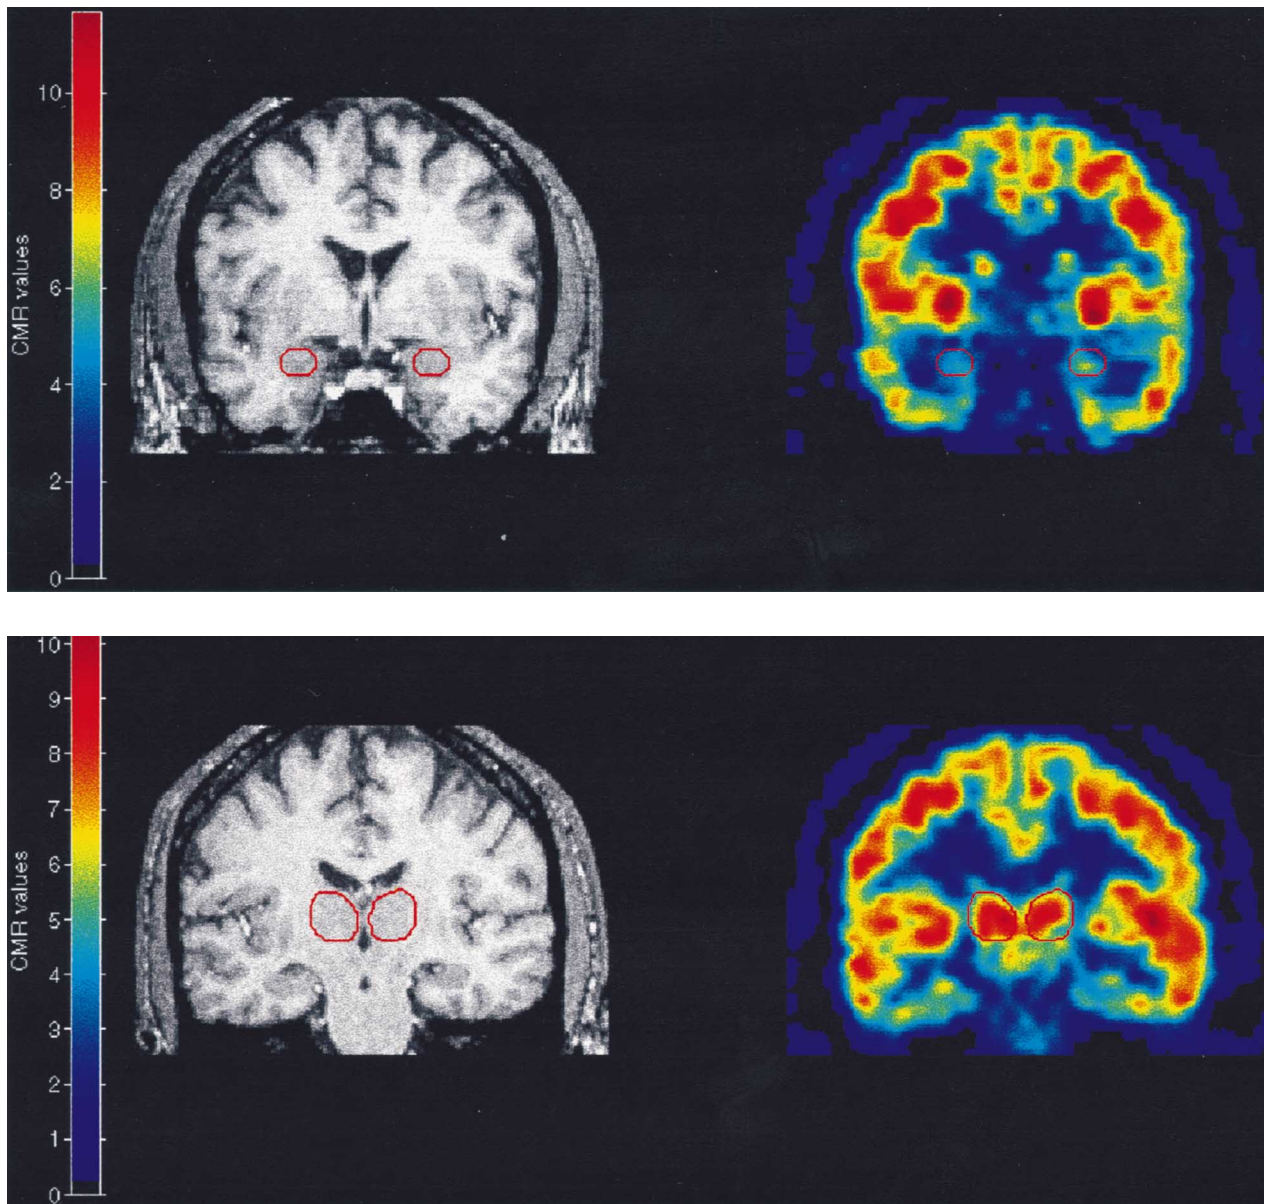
PET-MRI co-registration and amygdalar (a) or thalamic (b) ROI delineation. This figure presents representative image planes in the coronal orientation for one participant. The PET image planes are presented beside their corresponding co-registered MRI planes.²¹ Each actual amygdalar ROI included data from 5–8 planes and thalamic ROIs contained data from 25–41 planes. The PET image of absolute $rCMR_{glu}$ is from a GE Advance PET camera¹⁹ (in-plane resolution ~5 mm FWHM). Units of the PET color scale are in mg/100g/min.
